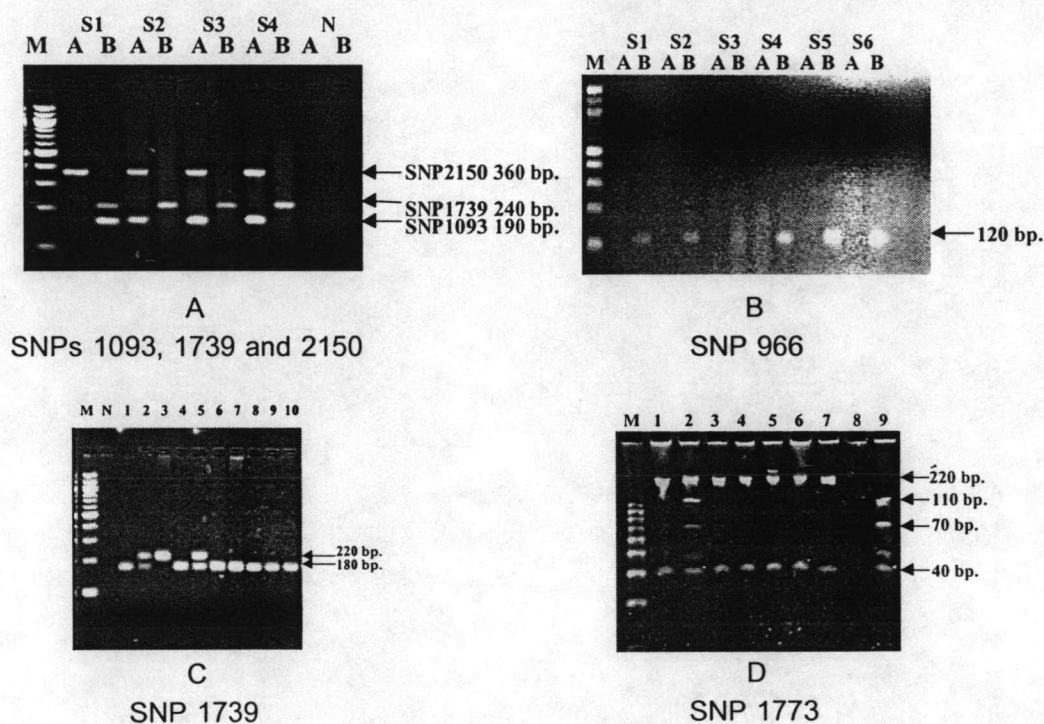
SNPs analysis of *PIRG* were investigated by ARMS and PCR-RFLP. (A) *PIRG*1093, 1739 and 2150 were detected by multiplex ARMS, N was the negative control for primer sets A and B. Sample S2, S3 and S4 were homozygous 1093G, 1739C and 2150G whereas S1 was homozygous 1093A, 1739C and 2150G. (B) *PIRG*966 was detected by single ARMS. Sample S1-S5 were homozygous T and 120 bp was the PCR product. (C) RFLP analysis of 220 bp *PIRG*1739 PCR products with *Hga*I digestion yielded 180 and 40 bp DNA fragments. Sample 1,4,6,7,8,9 and 10 were homozygous CC, sample 2 and 5 were heterozygous CT and sample 3 was homozygous TT, N represented negative control. (D) RFLP analysis of 220 bp *PIRG*1773 PCR products with *Msp*I digestion yielded 110, 70 and 40 bp DNA fragments. Sample 1,3,4,5,6 and 7 were homozygous TT, sample 2 was heterozygous CT and sample 9 was homozygous CC. Sample 8 could not amplify.
